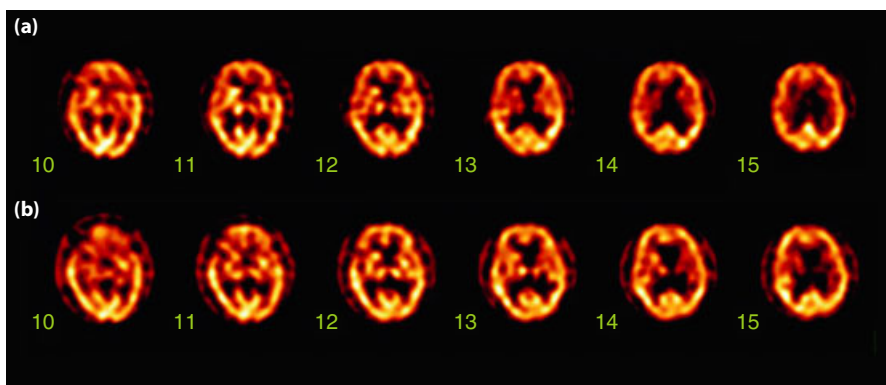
Brain technetium-99m ethyl cysteinate dimer single photon emission computed tomography (SPECT). (a) The first SPECT showing a high radioisotope uptake in the lower part of the right thalamus (number 11 and 12). (b) The high uptake is still observed in the right thalamus (number 12 and 13) in the second SPECT. Redistribution of thalamic blood flow with upward migration is considered.
